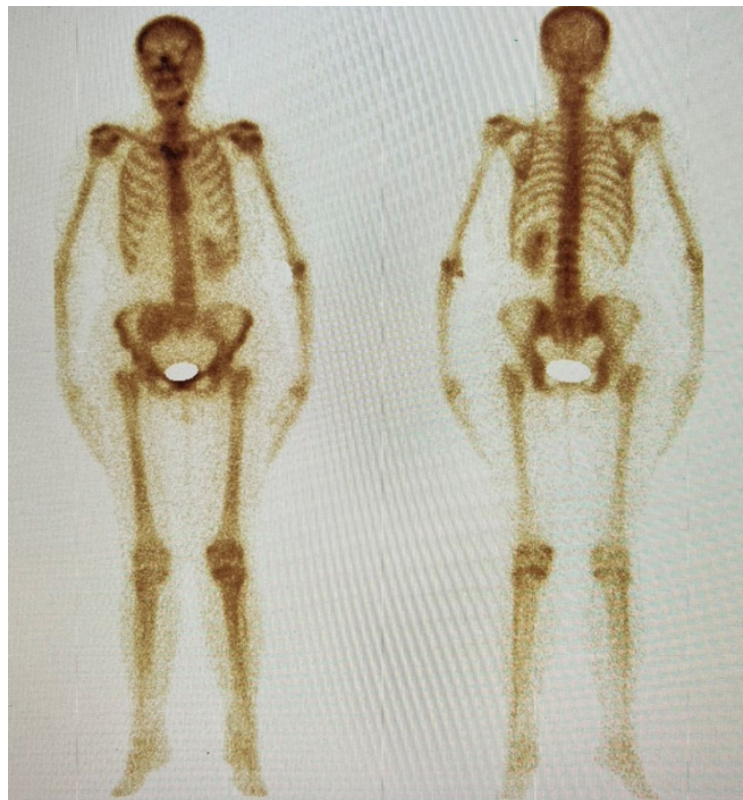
Bone scintigraphy.
